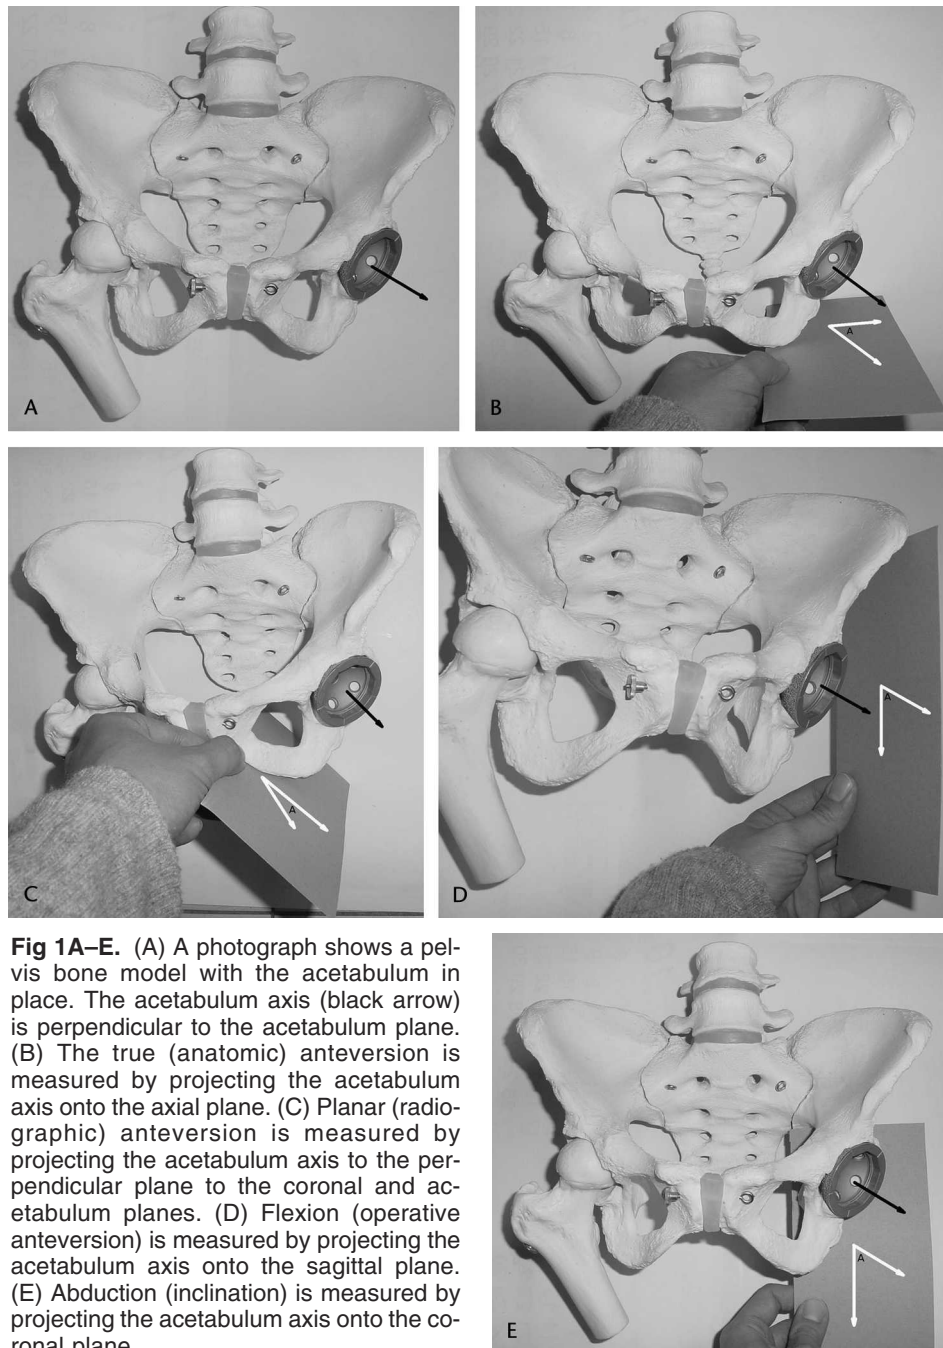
(A) A photograph shows a pelvis bone model with the acetabulum in place. The acetabulum axis (black arrow) is perpendicular to the acetabulum plane. (B) The true (anatomic) anteversion is measured by projecting the acetabulum axis onto the axial plane. (C) Planar (radiographic) anteversion is measured by projecting the acetabulum axis to the perpendicular plane to the coronal and acetabulum planes. (D) Flexion (operative anteversion) is measured by projecting the acetabulum axis onto the sagittal plane. (E) Abduction (inclination) is measured by projecting the acetabulum axis onto the coronal plane.
